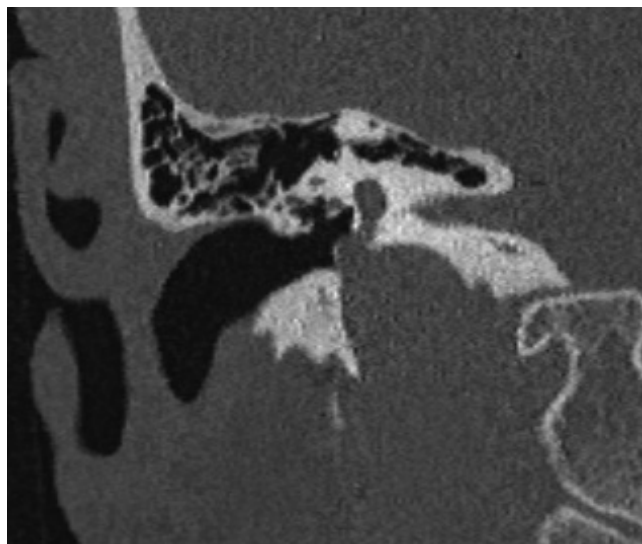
Coronal CT showing high riding right jugular bulb, protruding into hypotympanum.
